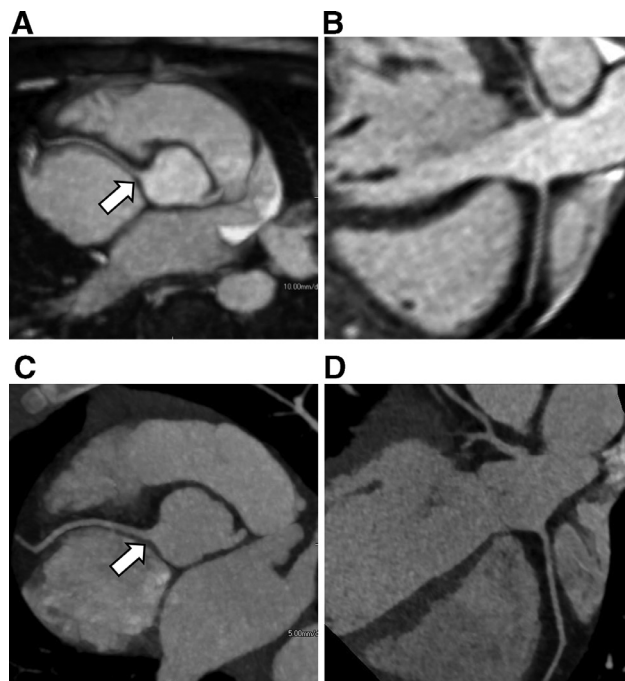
This 10-year-old girl had multiple recent episodes of chest pain. Echocardiography was inconclusive regarding a possible coronary anomaly. Both SN3D-MRA (A, B) and CTA (C, D) showed an anomalous origin of the RCA (arrows) from the "noncoronary" sinus.
